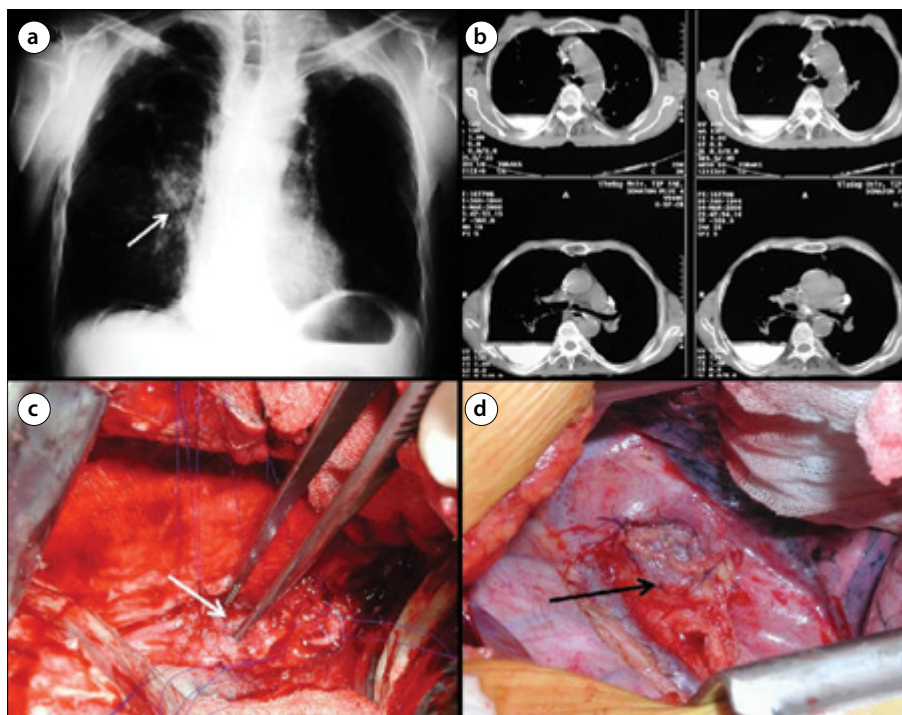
a-d. Photographs of a patient (Number 27). NG in right hemithorax at PA imaging (white arrow (a)), perforation at CT with oral contrast (b), site of perforation (white arrow shows perforation area (c), parietal flap (black arrow shows flap) (d).
